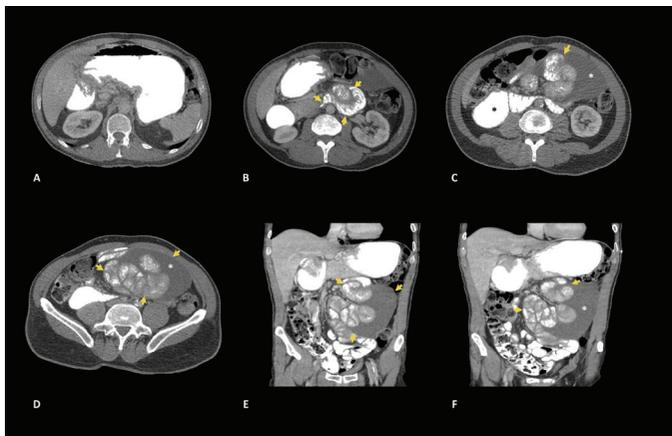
Axial (A-D) and coronal plane (E, F) contrast-enhanced abdominal computed tomography examination. Dilatation in the second part of the duodenum (black asterisk, A-C), decrease in the calibration of the fourth part of the duodenum at the aortomesenteric level (C), starting from the duodenojejunal junction, encapsulated with the jejunal loops (yellow arrows) in accordion form and surrounded by the fluid density (white asterisk). Slight thickening of the jejunal loops and wall (B-F)
